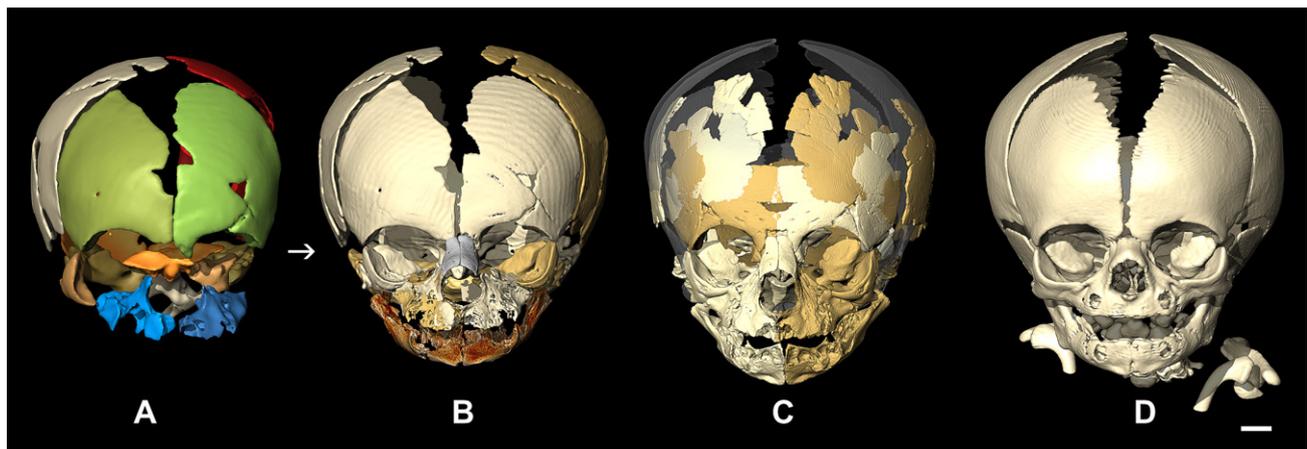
Virtual reconstructions of Mezmaiskaya, Le Moustier 2 and a modern human neonate. Segmentation of the original CT scan of Mezmaiskaya before (A) and after reconstruction (B). The two nasal bones (grey) are from Le Moustier 2. C: Virtual reconstruction of Le Moustier 2. Parts obtained via mirror-imaging are plotted in a darker shade; semitransparent surfaces were estimated based on complete reference crania. D: Modern human neonate. Scale bar is 10 mm.
